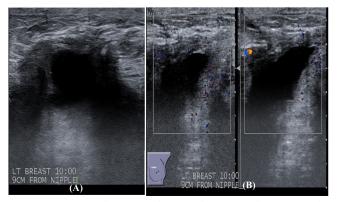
(A) Axial view and (B) Colour Doppler - example for false-positive case. Ultrasound images showed irregular, hypoechoiec lesion with posterior shadowing and thick wall at left breast 10 OC, adjacent to scar tissue (post wide local excision for previous left invasive ductal carcinoma). BI-RADS 5 was given and biopsy performed with HPE turn out to be breast abscess secondary to chronic granulomatous mastitis.
